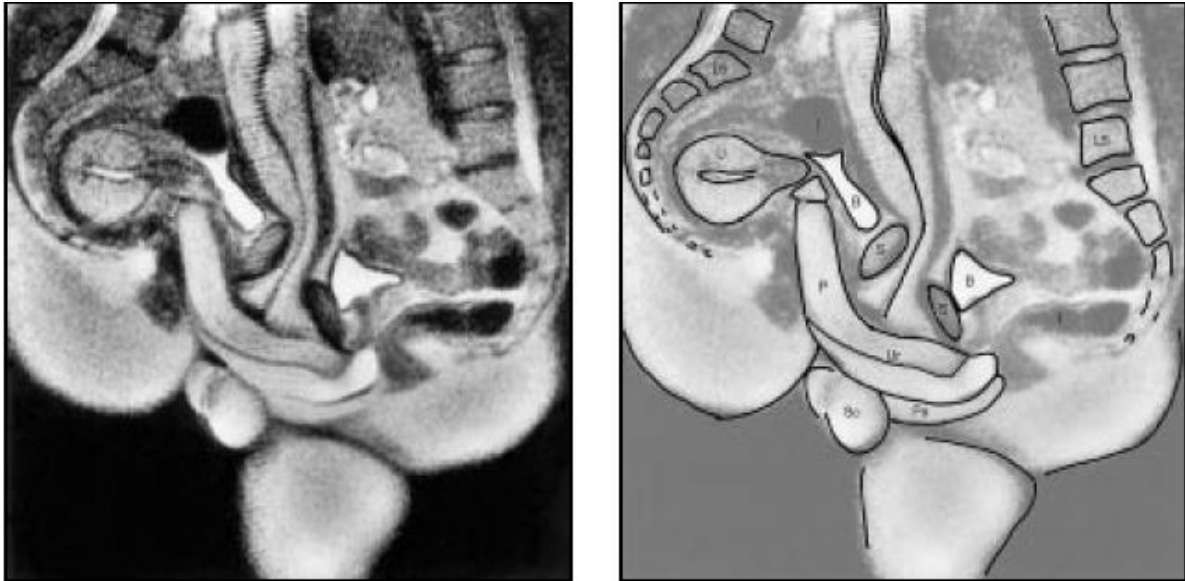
Midsagittal MRI image of the anatomy of sexual intercourse. (Schultz et al. 1999). The following abbreviation key is meant to orient the reader: P = penis, Ur = urethra, Pe = perineum, U = uterus, S = symphysis, B = bladder, I = intestine, L5 = lumbar, Sc = scrotum
